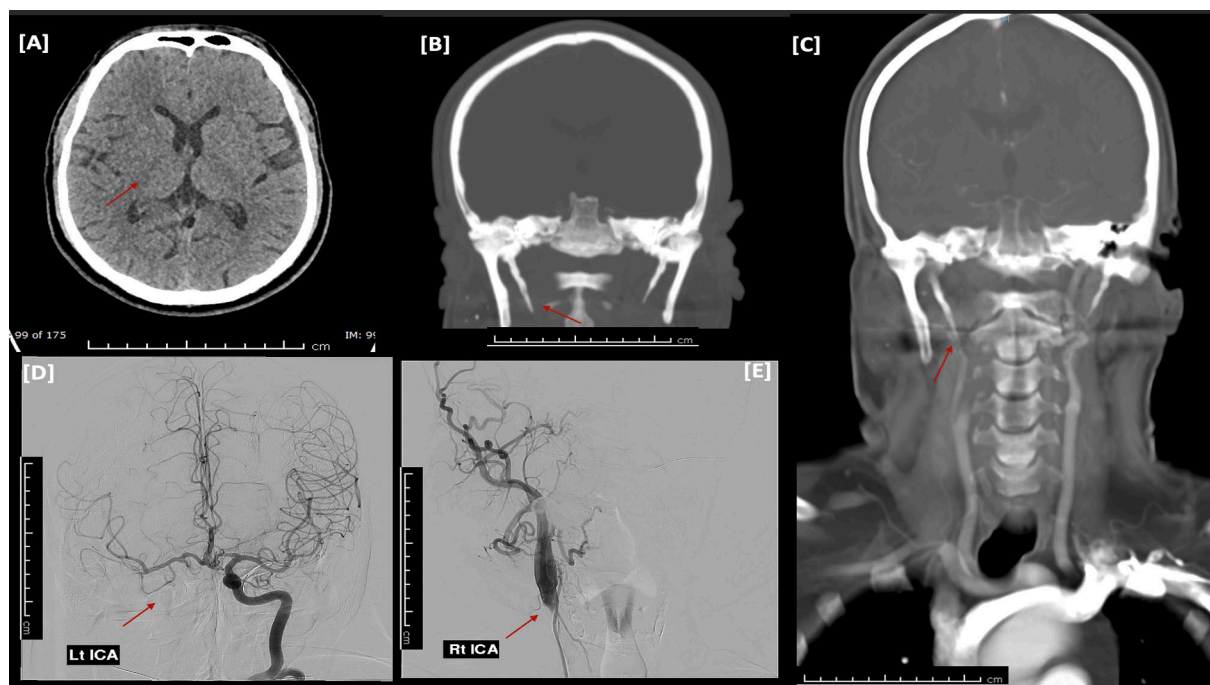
[A–E] Case one with right ICA dissection and elongated styloid processes. [A] Axial Non-contrast CT brain at the level of the basal ganglia and internal capsules showing subtle obscuration of the borders of the right lentiform nucleus raising the possibility of hyperacute ischemic insult along the right MCA territory. [B] Coronal MIP reconstructed images bony window algorithm showing elongated styloid processes bilaterally thicker and longer on the right side (>3cm). [C] Coronal reconstructed MIP CT angiogram showing the right elongated styloid process reaching the level of the occluded proximal right ICA at the level of the transverse process of C2 vertebra. [D and E] Conventional cerebral angiogram showing total occlusion with absent flow along the right internal carotid artery with refilling of its terminal cerebral branches from the contralateral left internal carotid artery injection.
